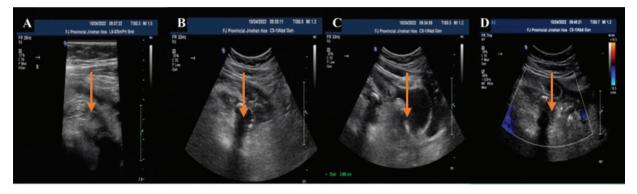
Ultrasound data of a nine-year-old female patient's right lower abdominal cavity (appendiceal region). Hypoechoic image inward and downward (A), irregular hypoechoic mass (B), wrapping (omental echo) (C), pelvic cavity (D).
